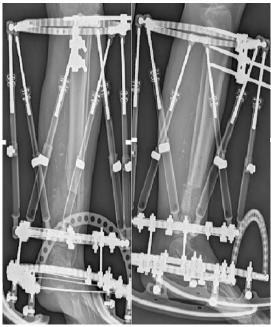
Control X-ray after second induced membrane time.
